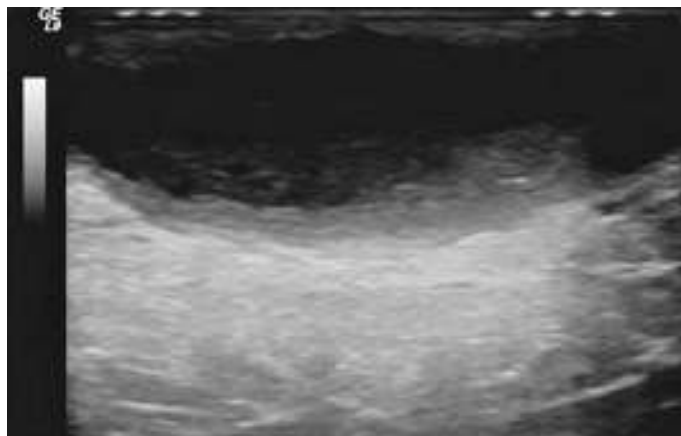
Ultrasound image showing a large hypoechoic area representing a large superficial abscess.
